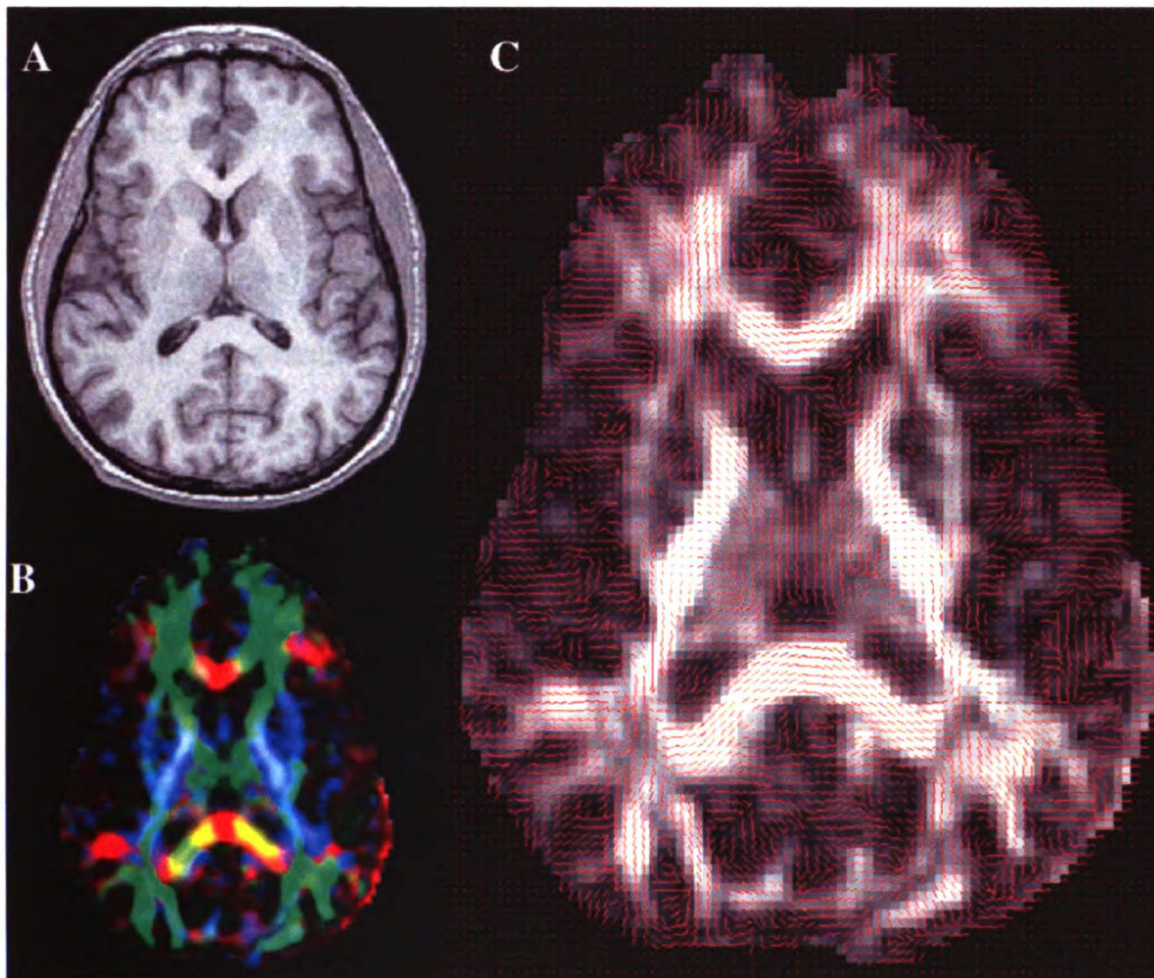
Diffusion tensor parameters. A) Conventional T1-weighted image B) Color overlay of primary eigenvector's direction. Red is Left-Right, Blue is
